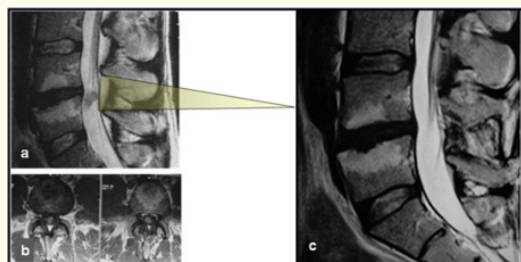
Sagittal (a) and axial T2 weighted (b) MRI images of posteriorly located lesion. The interlaminar triangle depicts the surgical corridor that could potentially be the safer, easier, more reachable and minimally invasive attempt. Postoperative sagittal T2 weighted MRI image is seen (c).
